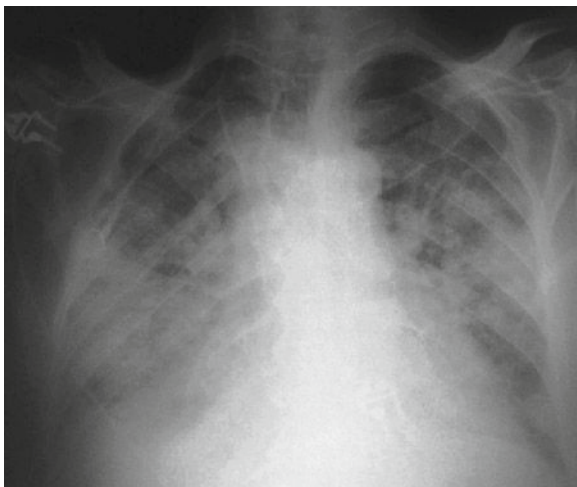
Chest X-ray at ICU admission
